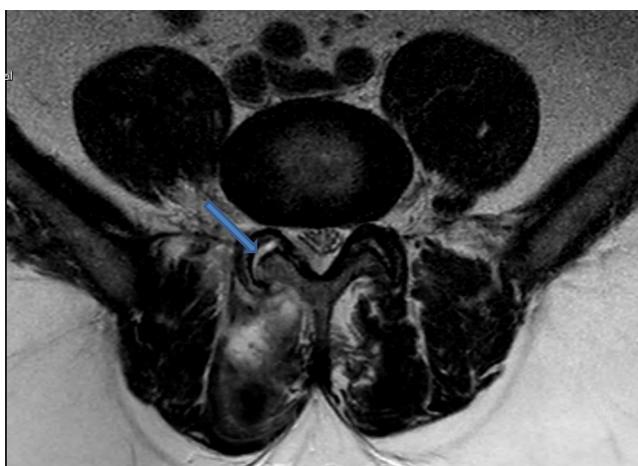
T2T weighted MRI image showing fluid collection in the right facet joint.
